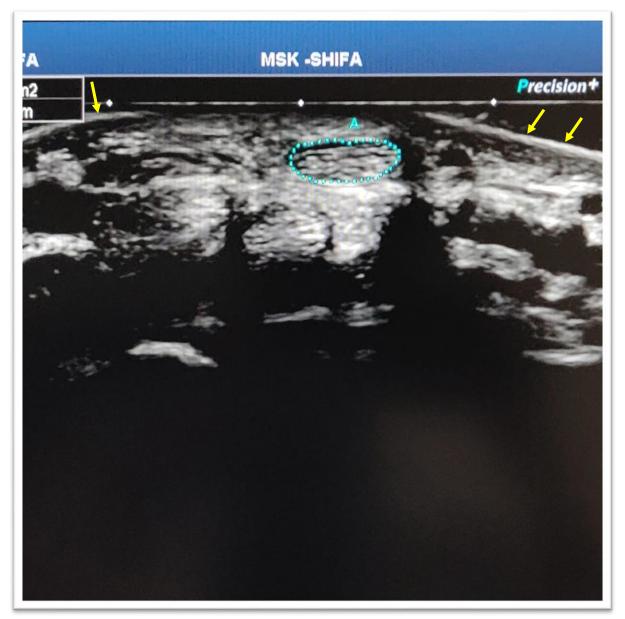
Ultrasound image of the wrist at the level distal wrist crease (carpal tunnel inlet). Notice the flexor retinaculum (yellow arrows). The median nerve has been outlined/manually traced (blue dotted line)
